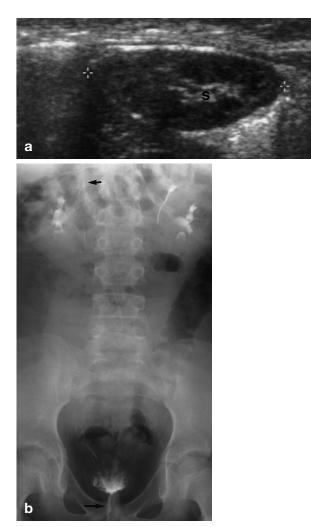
Abnormal US called normal; therefore, EU not done. Two-year-old girl hospitalized for pyelonephritis. a Ultrasound showed a right kidney that was normal except for an eccentric sinus (s). There was a normal left duplex kidney. VCUG showed grade 2 reflux on the left into a bifid ureter. Several more ultrasound exams were done and were called normal. Reflux resolved after three years. It was noticed that she constantly dribbled urine, but this was attributed to "voiding dysfunction related to vesicoureteric reflux" even after the reflux had resolved. Treatment of wetting included behavioral modification and prescription drugs from age 3 years 10 months until age 9 years 6 months, when a pediatric urologist was consulted. b EU showed a normal left duplex kidney. There was a poorly functioning right upper pole with a non-dilated upper pole calyx (upper arrow) and ureter. This ureter could be seen to drain below the base of the bladder (lower arrow). She underwent right upper-to-lower ureteroureterostomy and has been dry ever since
